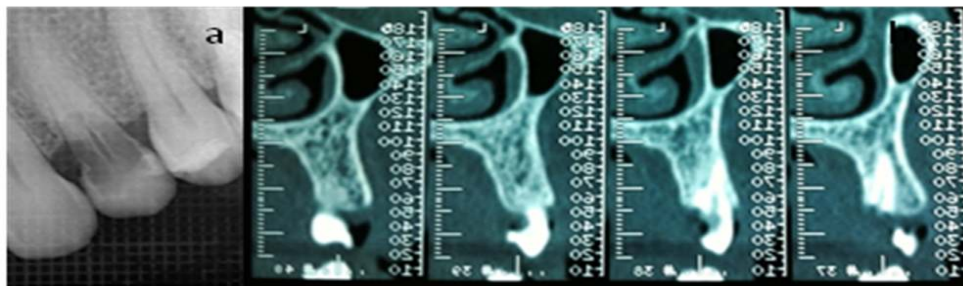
Radiographic control before surgery. (A) Periapical radiograph. (B) TC dental scan
